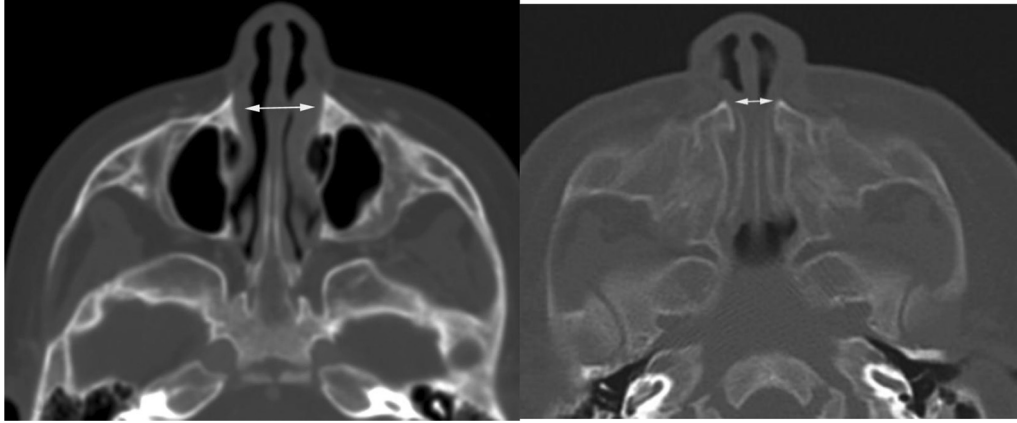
The width of the pyriform aperture is measured between the most medial segments of the frontal processes of the maxilla. On the left is an axial CT image of a normal 9-month-old female. On the right is a 9-month-old female with CNPAS. Note the arrows showing medial encroachment of the inferior portion of the maxillary frontal processes which seem to “pinch” the nasal aperture when compared with the normal infant on the left.
